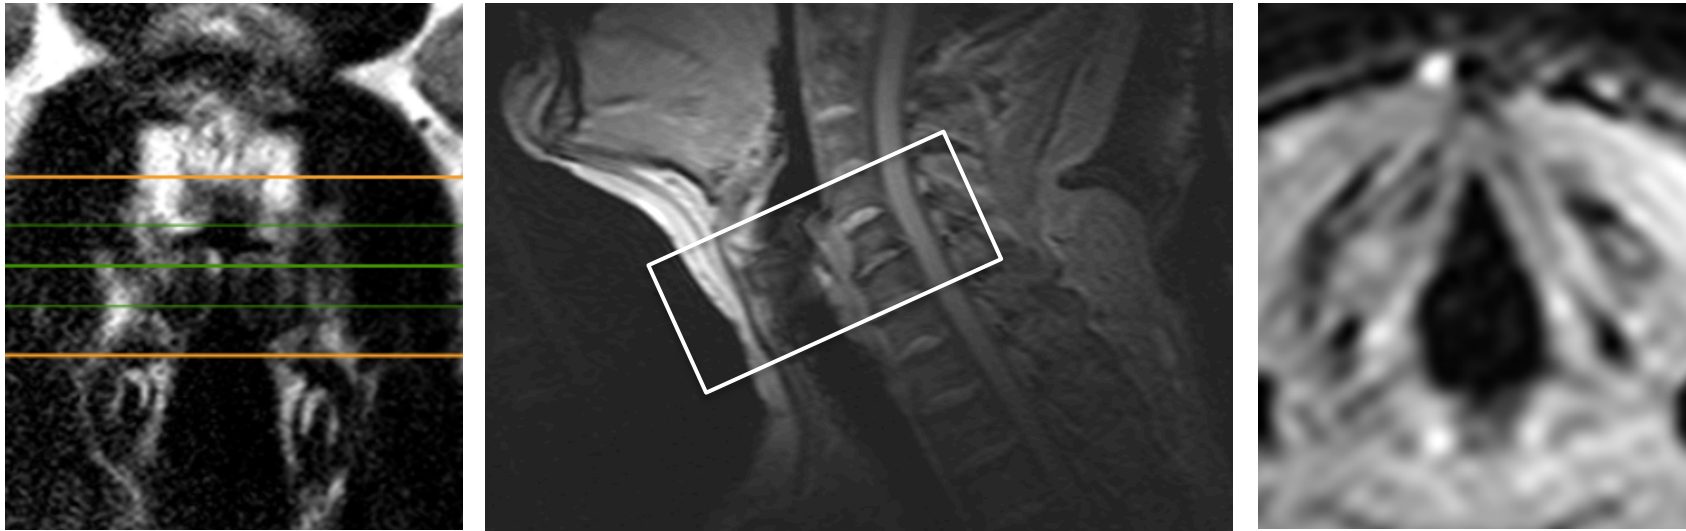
A) A T2-weighted coronal view of a participant showing three slices placement, two bold lines at the top and bottom and one line in the middle through the superior surface of the true vocal folds. B) A sagittal reference scan showing the angulation of the axial motion sequence positioned at right angles to the larynx. C) A frame from an axial motion sequence image of vocal folds during respiration.
